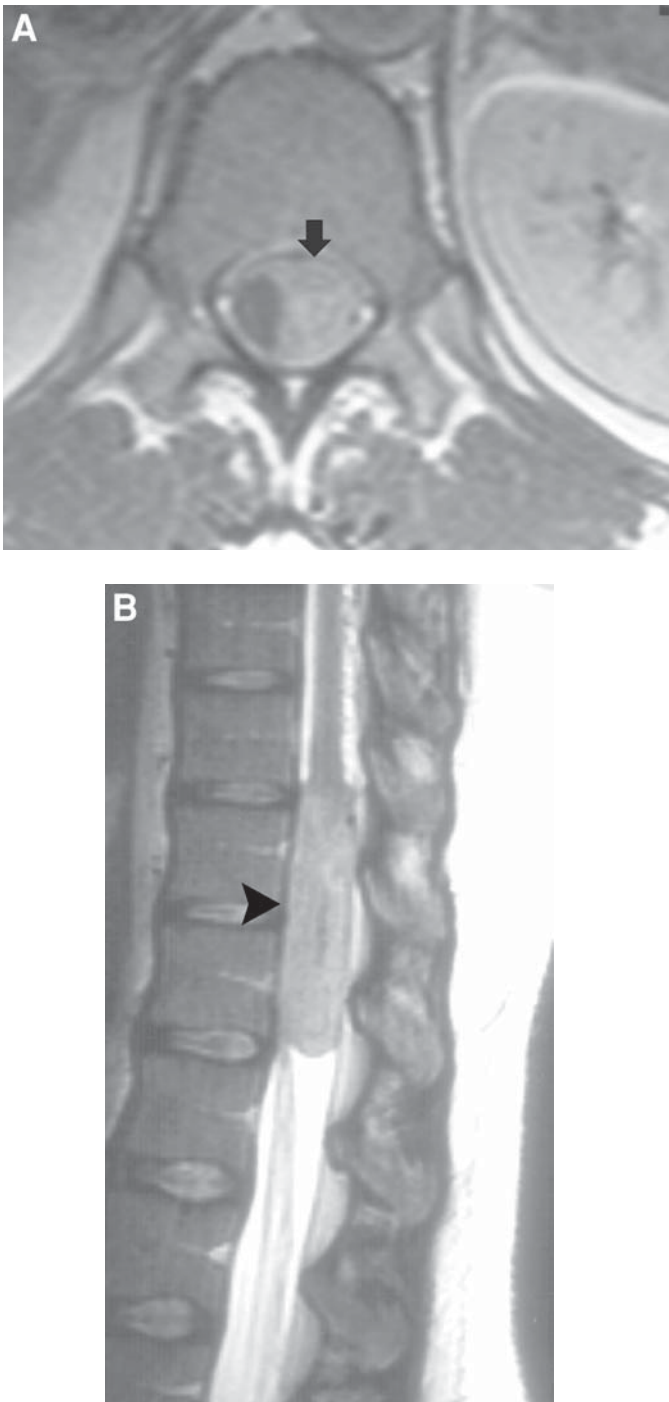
Ependymoma. Axial T1-weighted (A) and sagittal T2-weighted (B) images demonstrate a large soft tissue mass (*arrow and arrowhead*) in the region of the conus medullaris. The mass shows predominantly intermediate signal with areas of low and slightly increased signal. Myxopapillary ependymoma was found at surgery.
